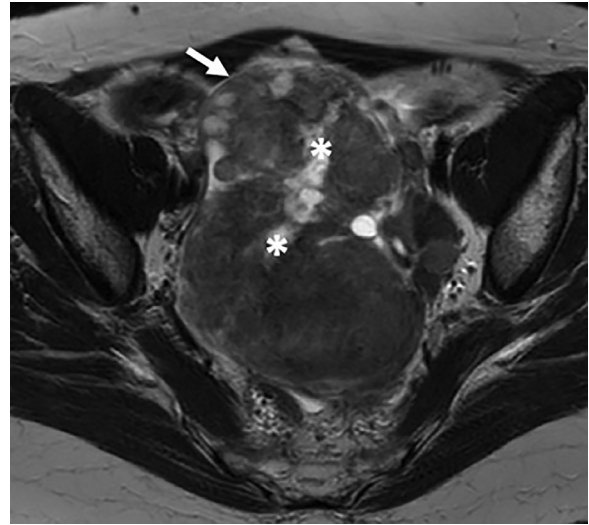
Axial T2-weighted image shows a well-defined solid mass (white arrow) located in the pelvis, with intermediate signal intensity and areas of hyperintensity consistent with cystic areas (*).
